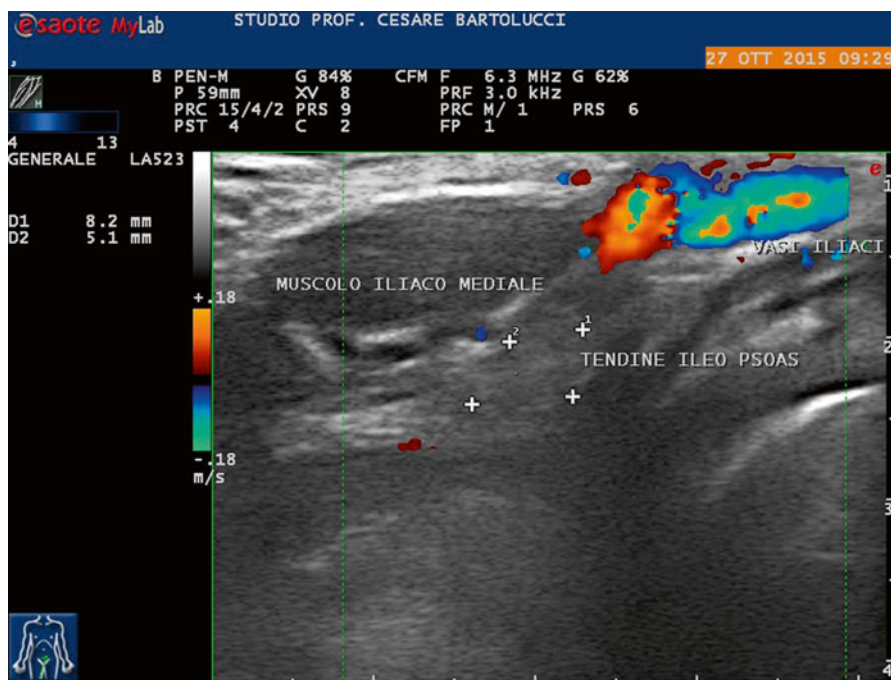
Sonographic view of iliopsoas tendon
